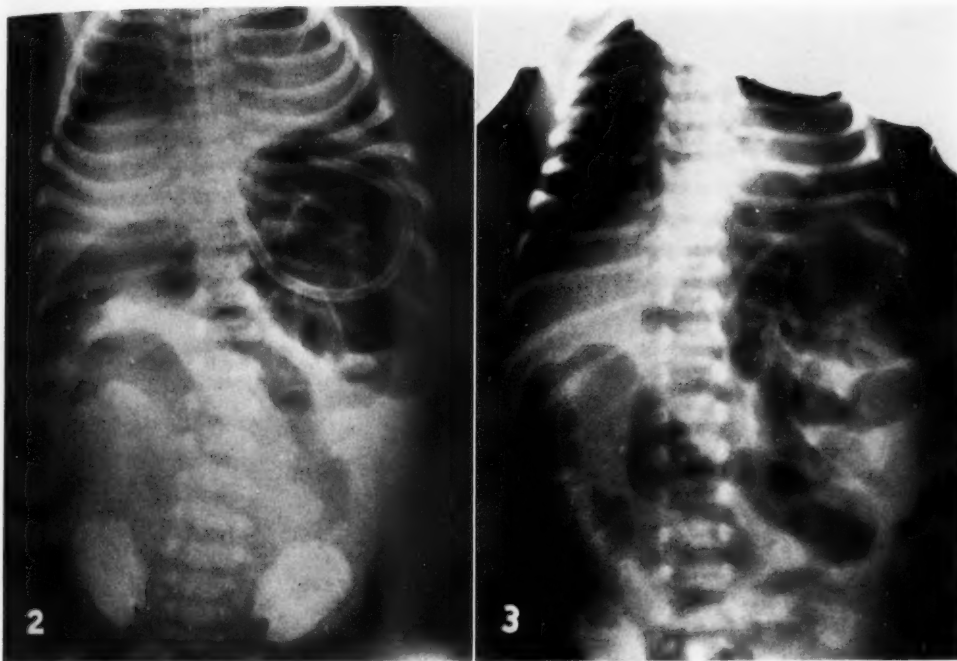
Supine roentgenogram of abdomen of newborn child with meconium ileus. Distended loops of bowel plus multiple small collections of gas mixed with meconium in right abdomen.
